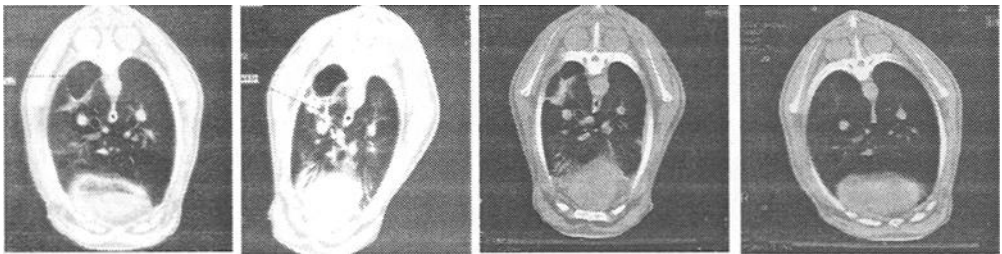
Serial CT images showing the lung at the EMPH time point pre-treatment (left), at the time of treatment (image 2), at BVR-1 (image 3), and at BVR-2 (right). The images document the progression of change from a 5 cm bulla to a collapsed scar over three months.
